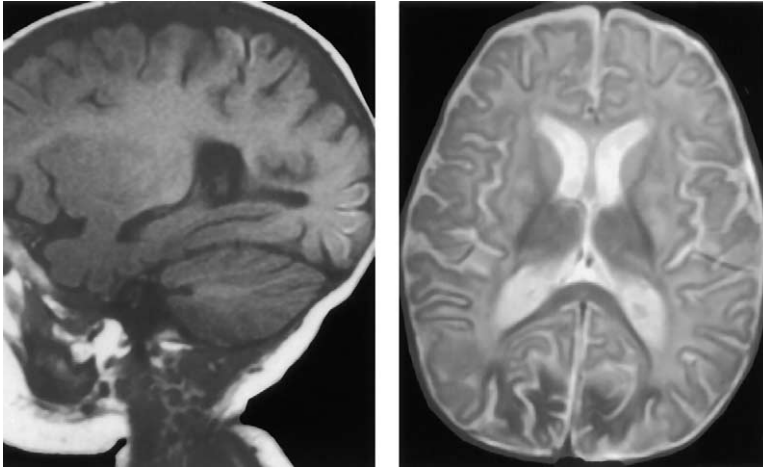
Sagittal T1-weighted image of an asphyxiated child demonstrating hyperintense laminar necrosis of occipital cortex and portion of the posterior frontal lobe (*left*). Axial T2-weighted image demonstrates hyperintense basal ganglia, and the T2 shortening (hypointense) occipital region caused by the laminar necrosis (*right*).
